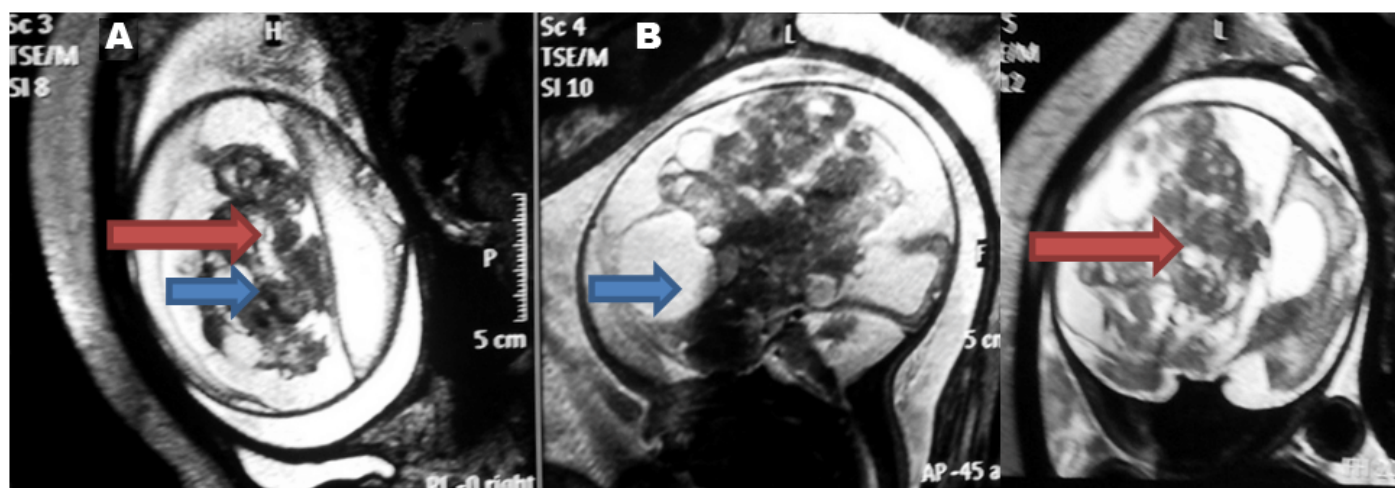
(A) T2 Axial with sagittal, and (B) T2 coronal shows well defined large lobulated intracranial supratentorial iso-hypoechoic lesion (red arrow) epicentered in midline with right sided extension causing significant dilatation of B/L lateral ventricles with intra-lesional variable sized T2 hyperintense internal cystic changes (blue arrow). Tiny calcifications are not well appreciated on magnetic resonance imaging.
